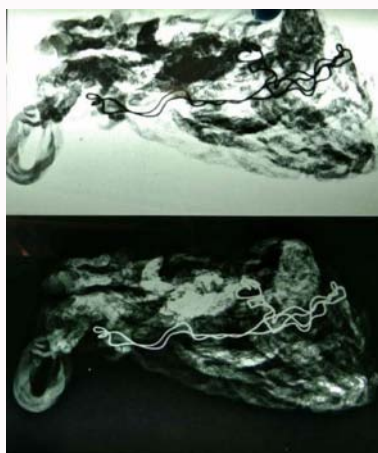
Postoperative radiograph of excised foreign body showing radio-opaque marker.
